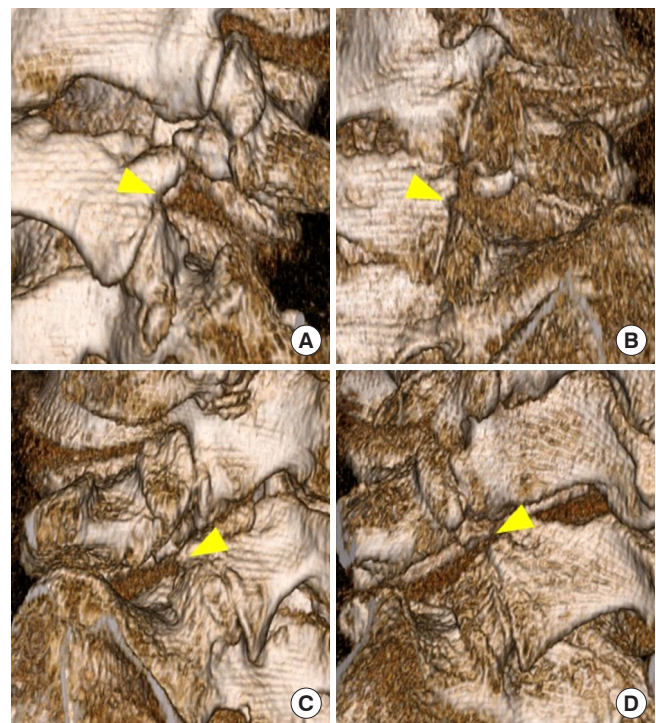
Three-dimensional computed tomography images of cases combined with spondylolysis. Four cases with spondylolysis could be treated without superior articular process (SAP) removal (A, case 2; B, case 4; C, case 5; D, case 11). The arrowheads indicate the narrowed cranial portion of the SAP and exposed entry point on the L5/S1 disc surface.
